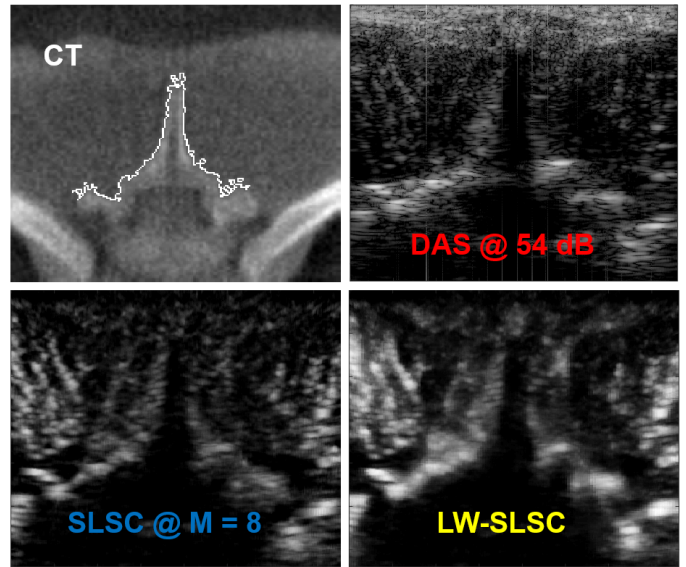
Examples of reconstructed CT (46.8 mm axial x 45.4 mm lateral), DAS, SLSC and LW-SLSC images (40 mm axial x 38.4 mm lateral) of the caprine sample (non-registered).
